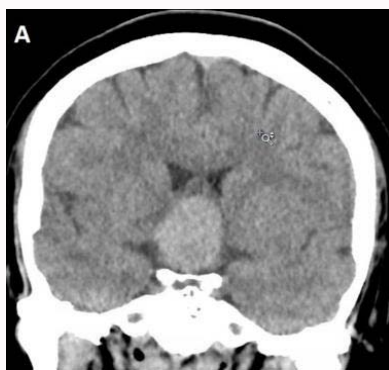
Initial CT: Sella and suprasellar structures.
